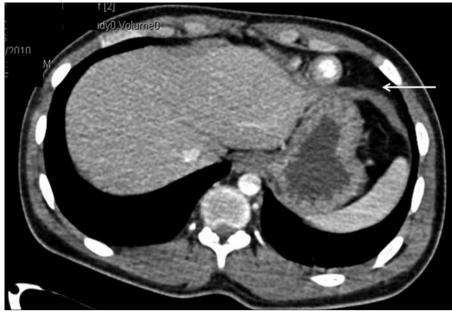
The axial helical CT scan shows thickening of the left hemidiaphragm (arrow).
